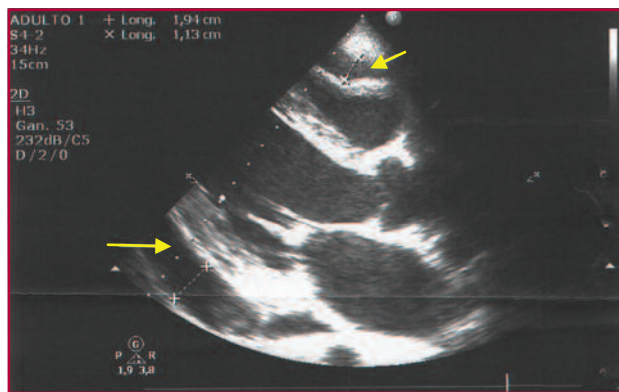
Transthoracic echocardiography. Parasternal long-axis view. A severe circumferential pericardial effusion is observed, 16 mm posteriorly and 6 mm anteriorly, with early diastolic collapse of the right ventricular anterior wall
